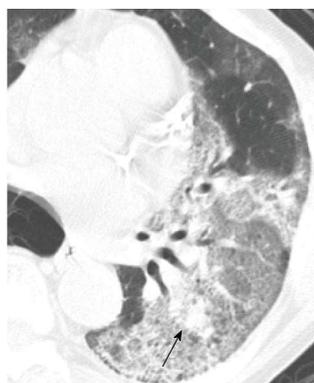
Legionella pneumophila* pneumonia in a man in his 50s. Thin-section computed tomography shows extensive ground-glass opacity (GGO) in the left lower lobe intermingled with focal consolidations that are sharply demarcated from the surrounding GGO (arrow).
